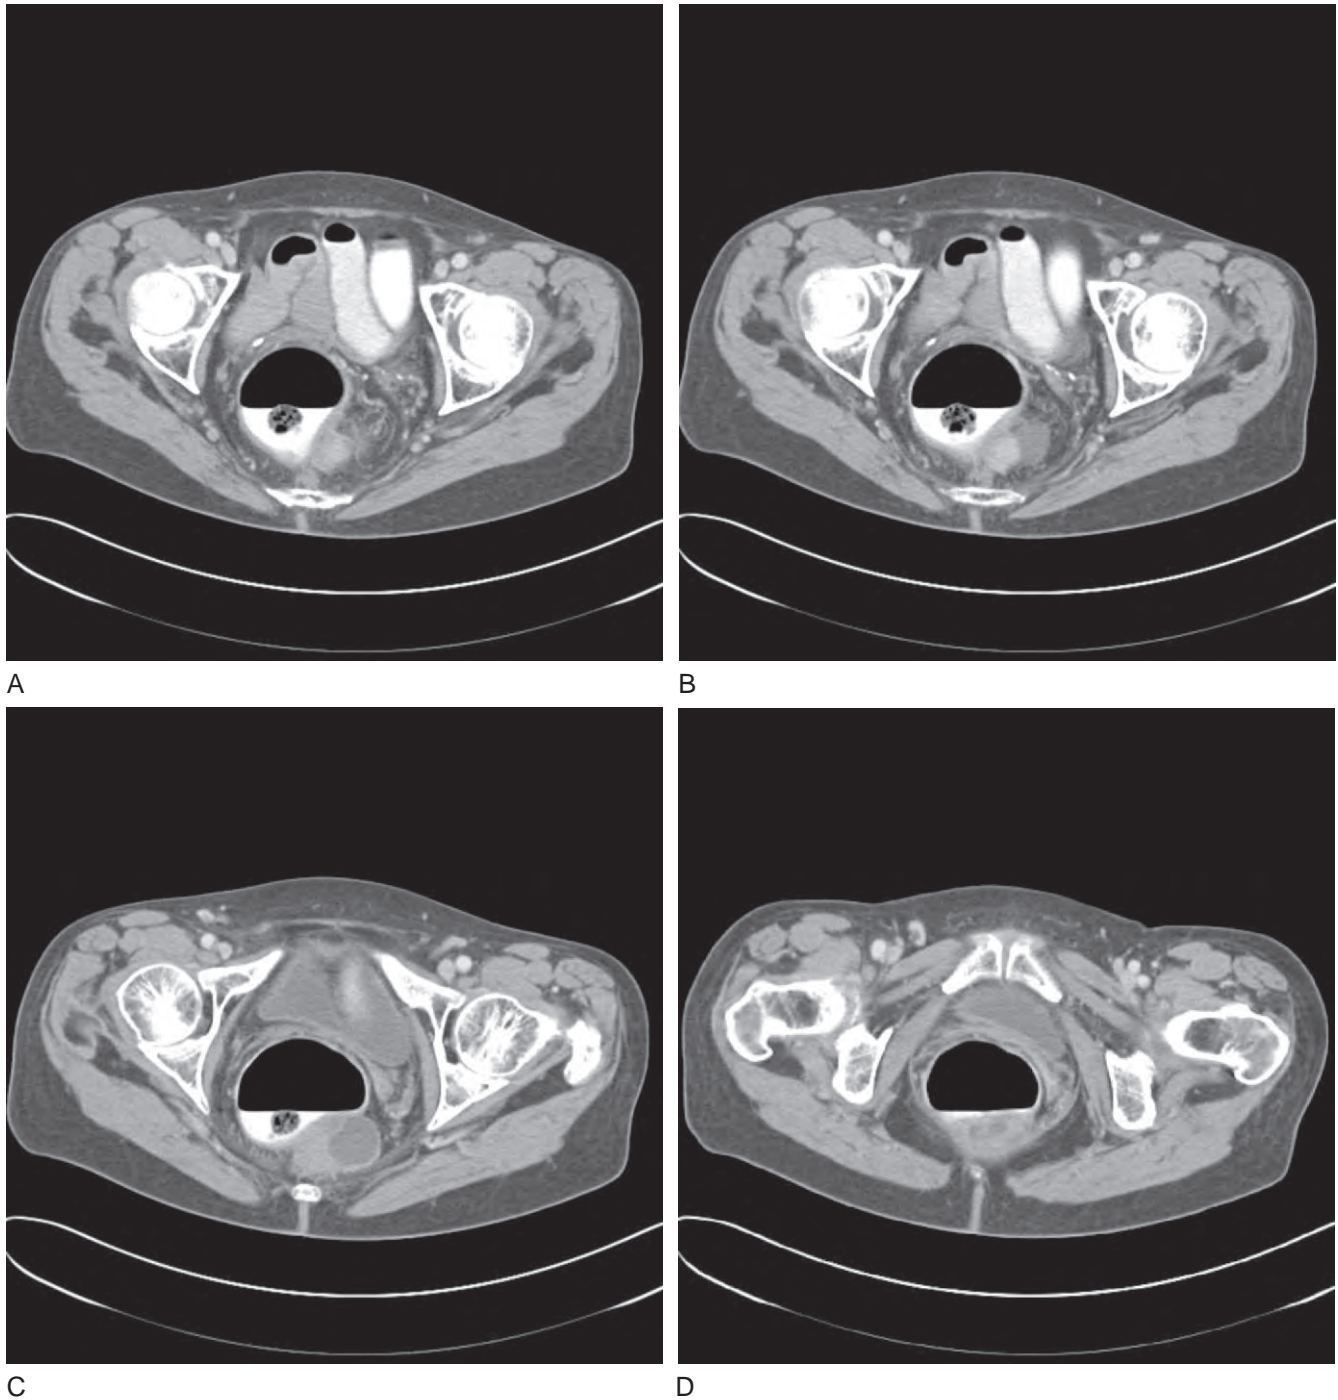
Computed tomography scan of a 74-year-old woman with a complex cystic left retrorectal mass. This tailgut cyst was approached laparoscopically during concomitant cholecystectomy.
